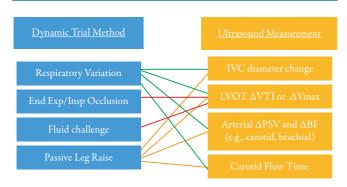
Dynamic trial methods and corresponding ultrasound measurement techniques that can be used. Note that the ultrasound measurement occurs before (pre) and after (post) the dynamic trial method, and the % change is used as a predictor for fluid responsiveness. The colored lines represent well known pairings of dynamic trial and ultrasound measurement methods, but is not intended to be entirely inclusive, such as non-ultrasound measurements like those involving arterial lines.
